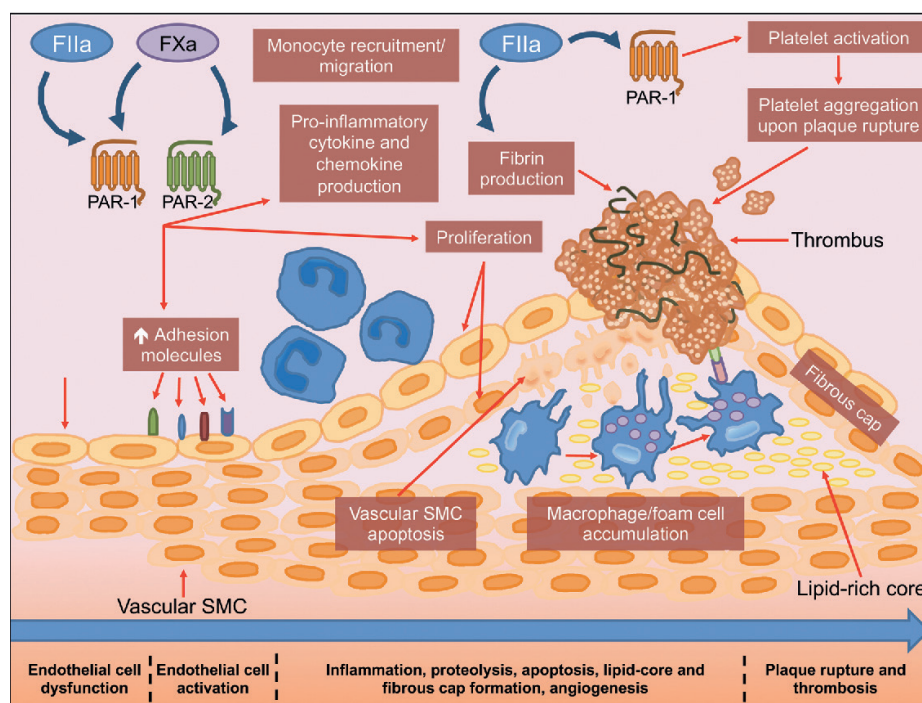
Pathophysiology of atherothrombosis and effect of dual pathway inhibition. Reproduced with permission, from: Esmon CT. Targeting factor Xa and thrombin: impact on coagulation and beyond. *Thromb Haemost.* 2014; 111(4): 625–633, doi: 10.1160/TH13-09-0730, indexed in Pubmed: 24336942
